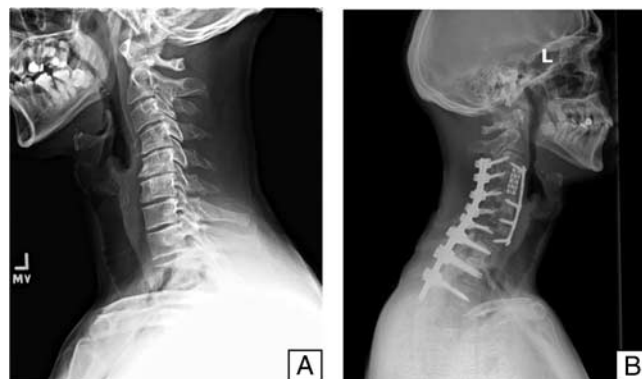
Lateral preoperative (A) and one-year postoperative (B) radiographs of a 50-year-old patient who had a 47.4% probability of developing distal junctional kyphosis postoperatively by the novel risk index.
